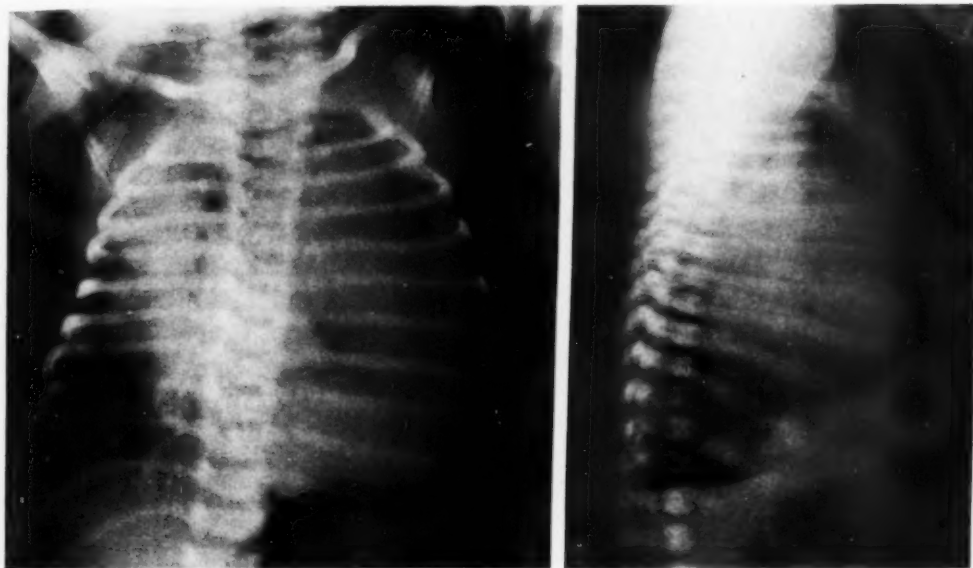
Non-communicating cystic hamartoma. The anomalous lobe is expanded and dense, resembling tumor. This type occurs when bronchial communication is not established, and the mass becomes completely filled with fluid secretions, producing a density instead of a hyperventilated area on the roentgenogram. (Compare with Fig. 10.)
